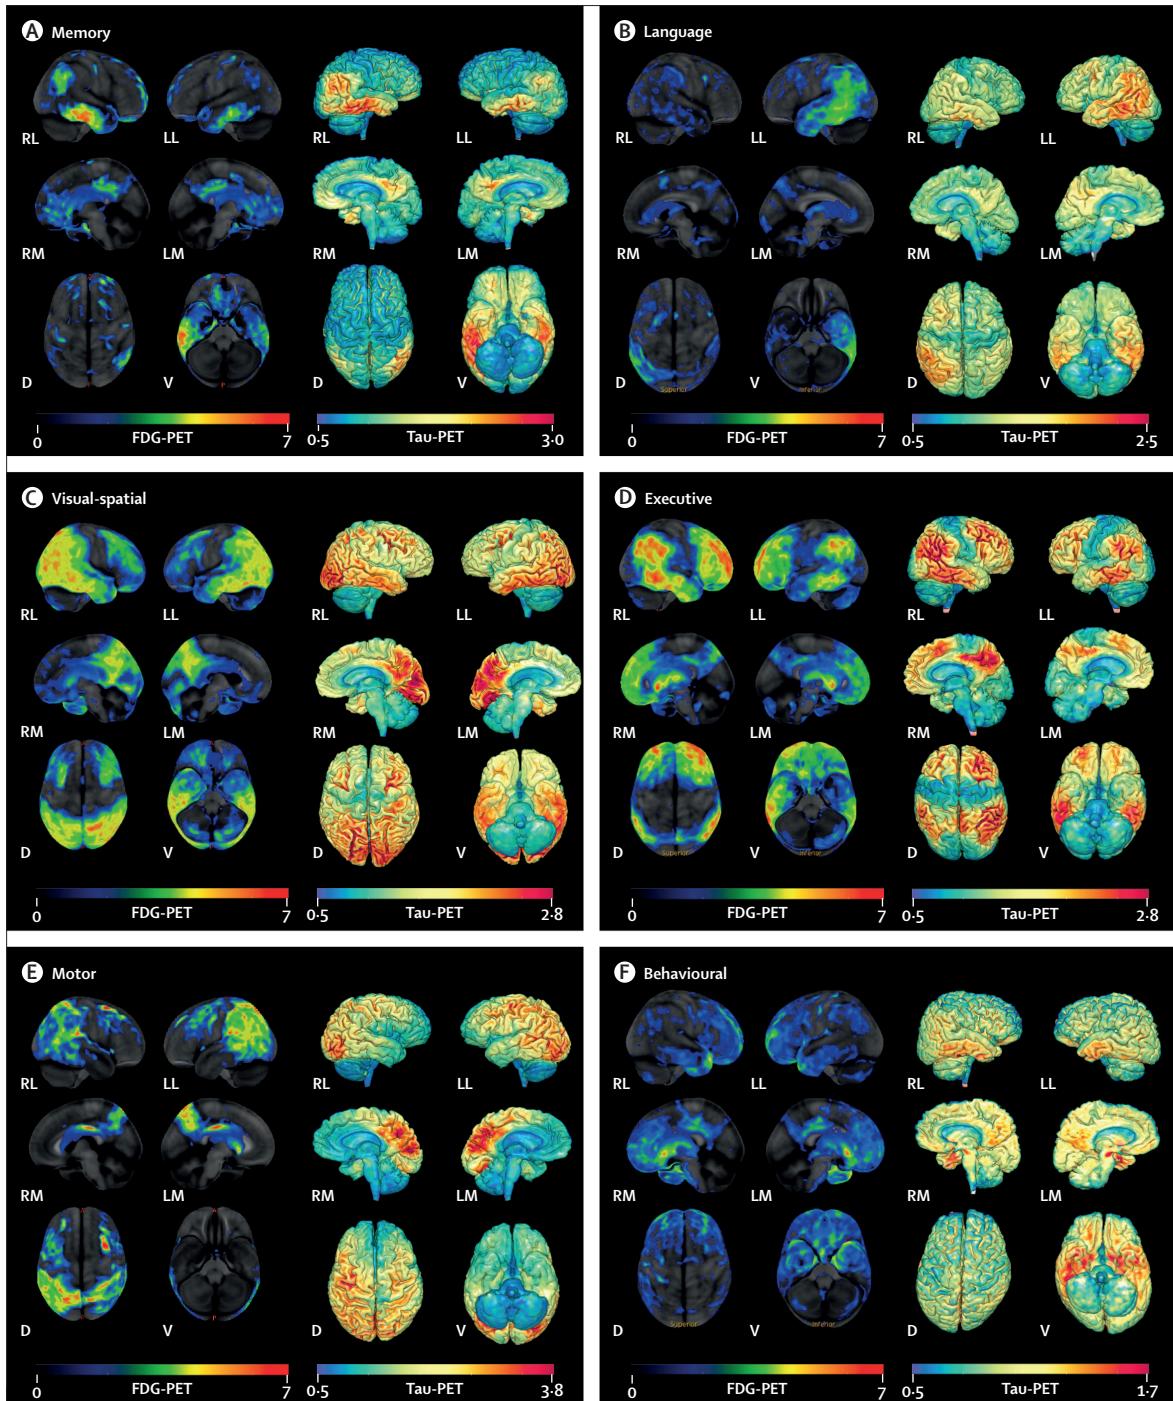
FDG and tau PET across Alzheimer's disease phenotypes
